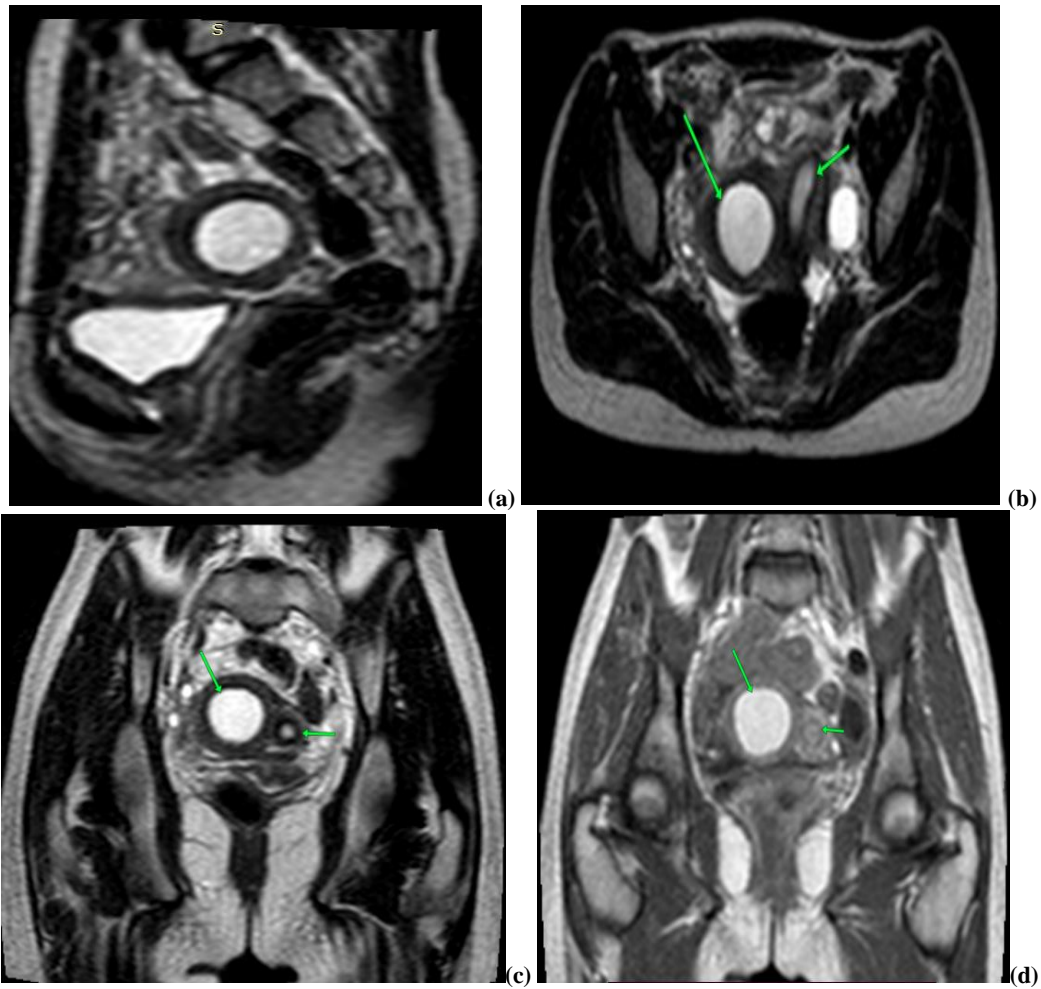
sagittal T2(a), axial T2(b),coronal T2(c),T1 post contrast(d). MRI images showing Well defined lesion inseparable from the right lateral wall of the uterus measuring 4.5x5 cm with internal blood signal showed bright signal in all series with marginal dark signal. Unicornuate AVF uterus showed normal size and MR signal. Unicornuate uterus with non-communicating functional rudimentary horn.
